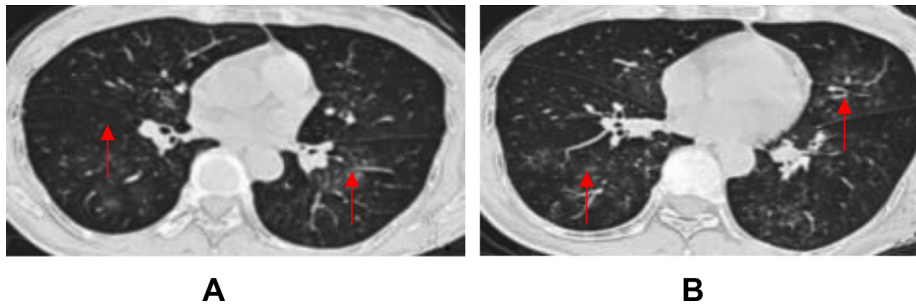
Female patient, 37 years old, no relevant contact history; CT examination; multiple peribronchial nodules, consolidation of GGO, the distribution of lesions is different, mainly for the central nodules (see the red arrows).
